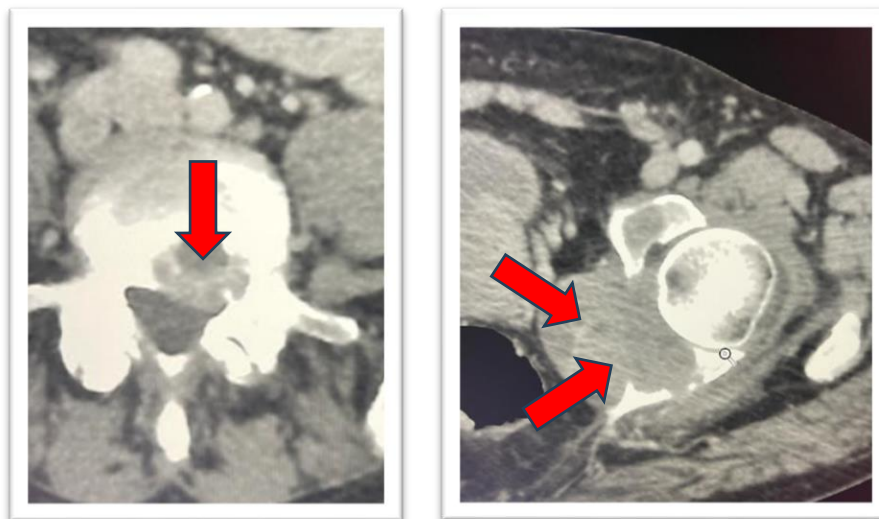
Lumbar-sacral-pelvic CT. A: osteolytic lesion at L5 (arrows); B: recurrent lesion at the left hip joint (arrows).
